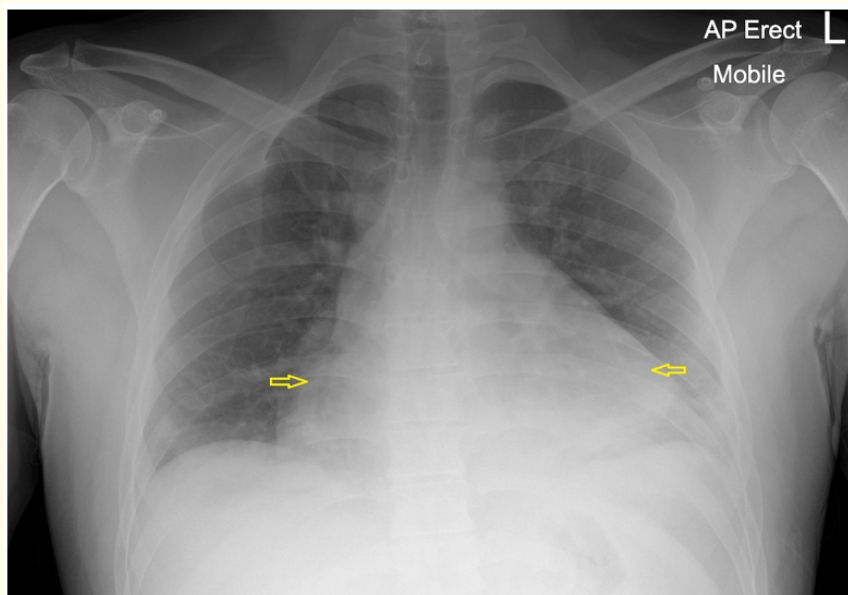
AP erect chest x-ray reveals enlarged cardiac shadow (arrows) and increased shadowing at the left base.
